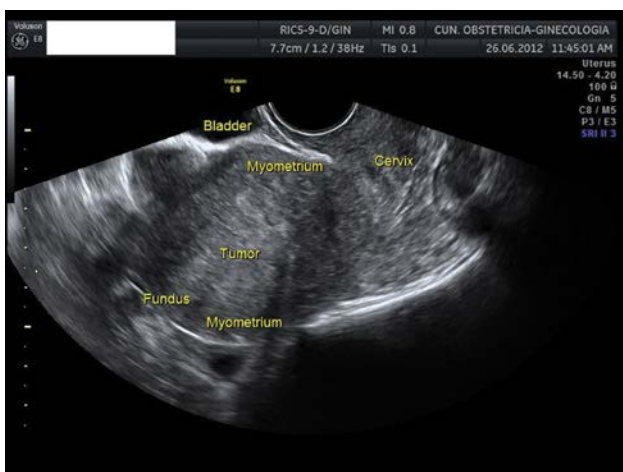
Transvaginal ultrasound showing a large endometrial lesion corresponding to an endometrial carcinoma (tumor). The tumor invades deeply the myometrial wall at the level of the fundus and posterior wall.
